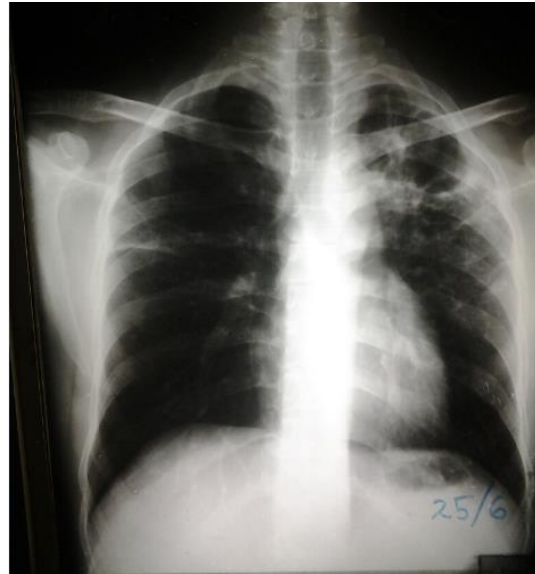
Chest radiograph showing significant resolution of the pulmonary lesions
